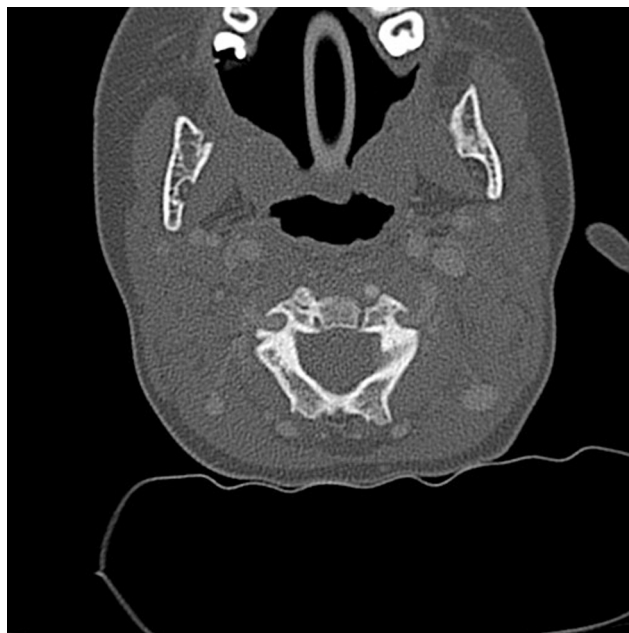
Computed tomography imaging of the relationship of the vertebral artery suggests that the axis is not amenable to safe placement of pedicle or transarticular screws.
